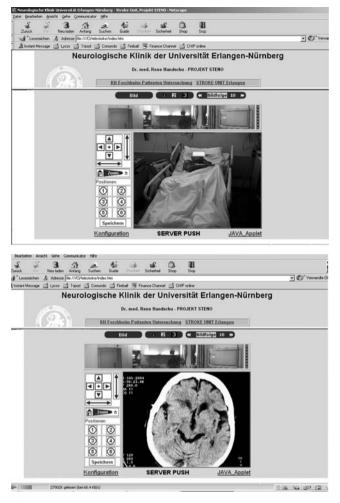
Patient and CT scan (one slice) viewed by the EVITA video camera
